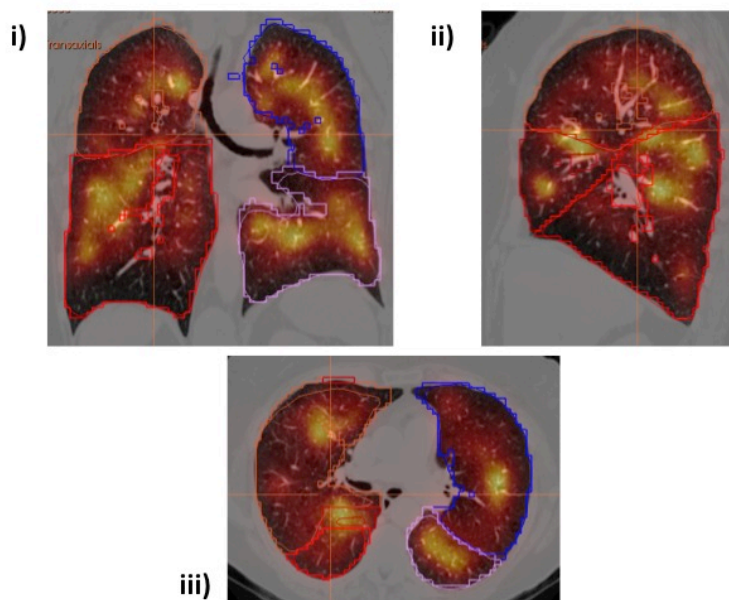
Selected NM-Q SPECT/CT images from OXF0068. Images are in the i) coronal, ii) sagittal and iii) axial plane and demonstrate relatively homogeneous perfusion signal in all pulmonary lobes.
